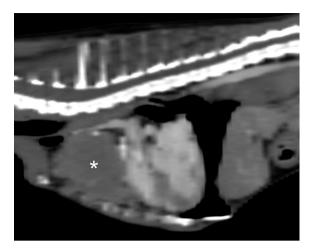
CT image of the thoracic region. A large mass (asterisk) is located anterior to the heart.
